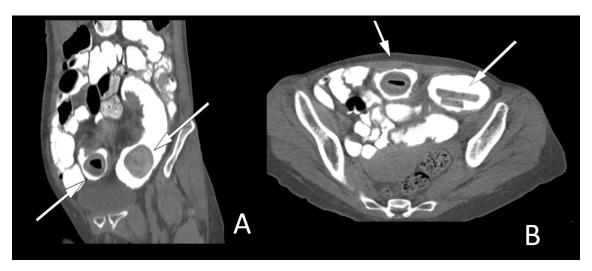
Abdominal computed tomography performed five days after the first one with oral contrast in the coronal (A) and axial (B) planes, showing the formations in the loops.
